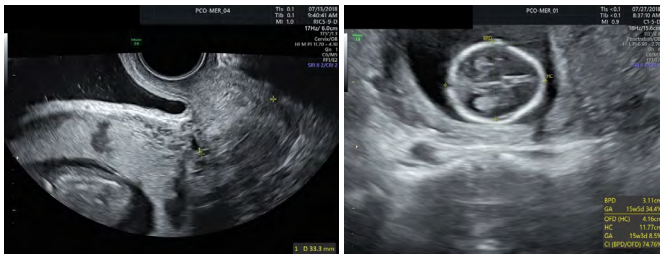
Definite placenta accreta with placenta previa and concern for placenta increta and fetal growth ultrasound within normal limits with a fetus measuring in the thirty-fourth percentile for gestational age.
